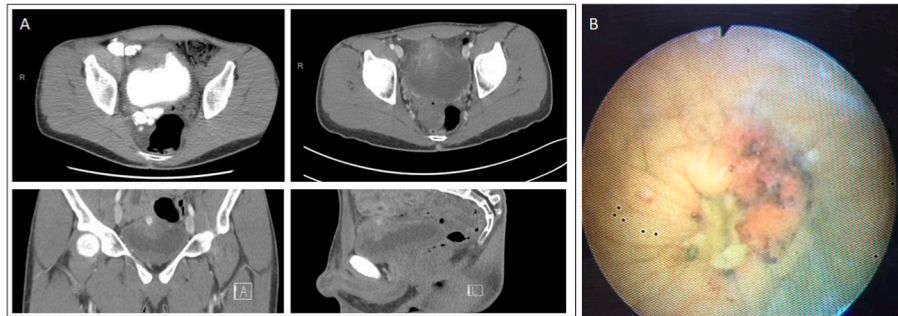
CT and cystoscopic imaging of bladder mass. A) CT cystogram with transverse image, and CT with IV contrast with transverse, coronal, and sagittal images. B) Cystoscopy showing large ulcerating mass at the dome of the patient's bladder.
